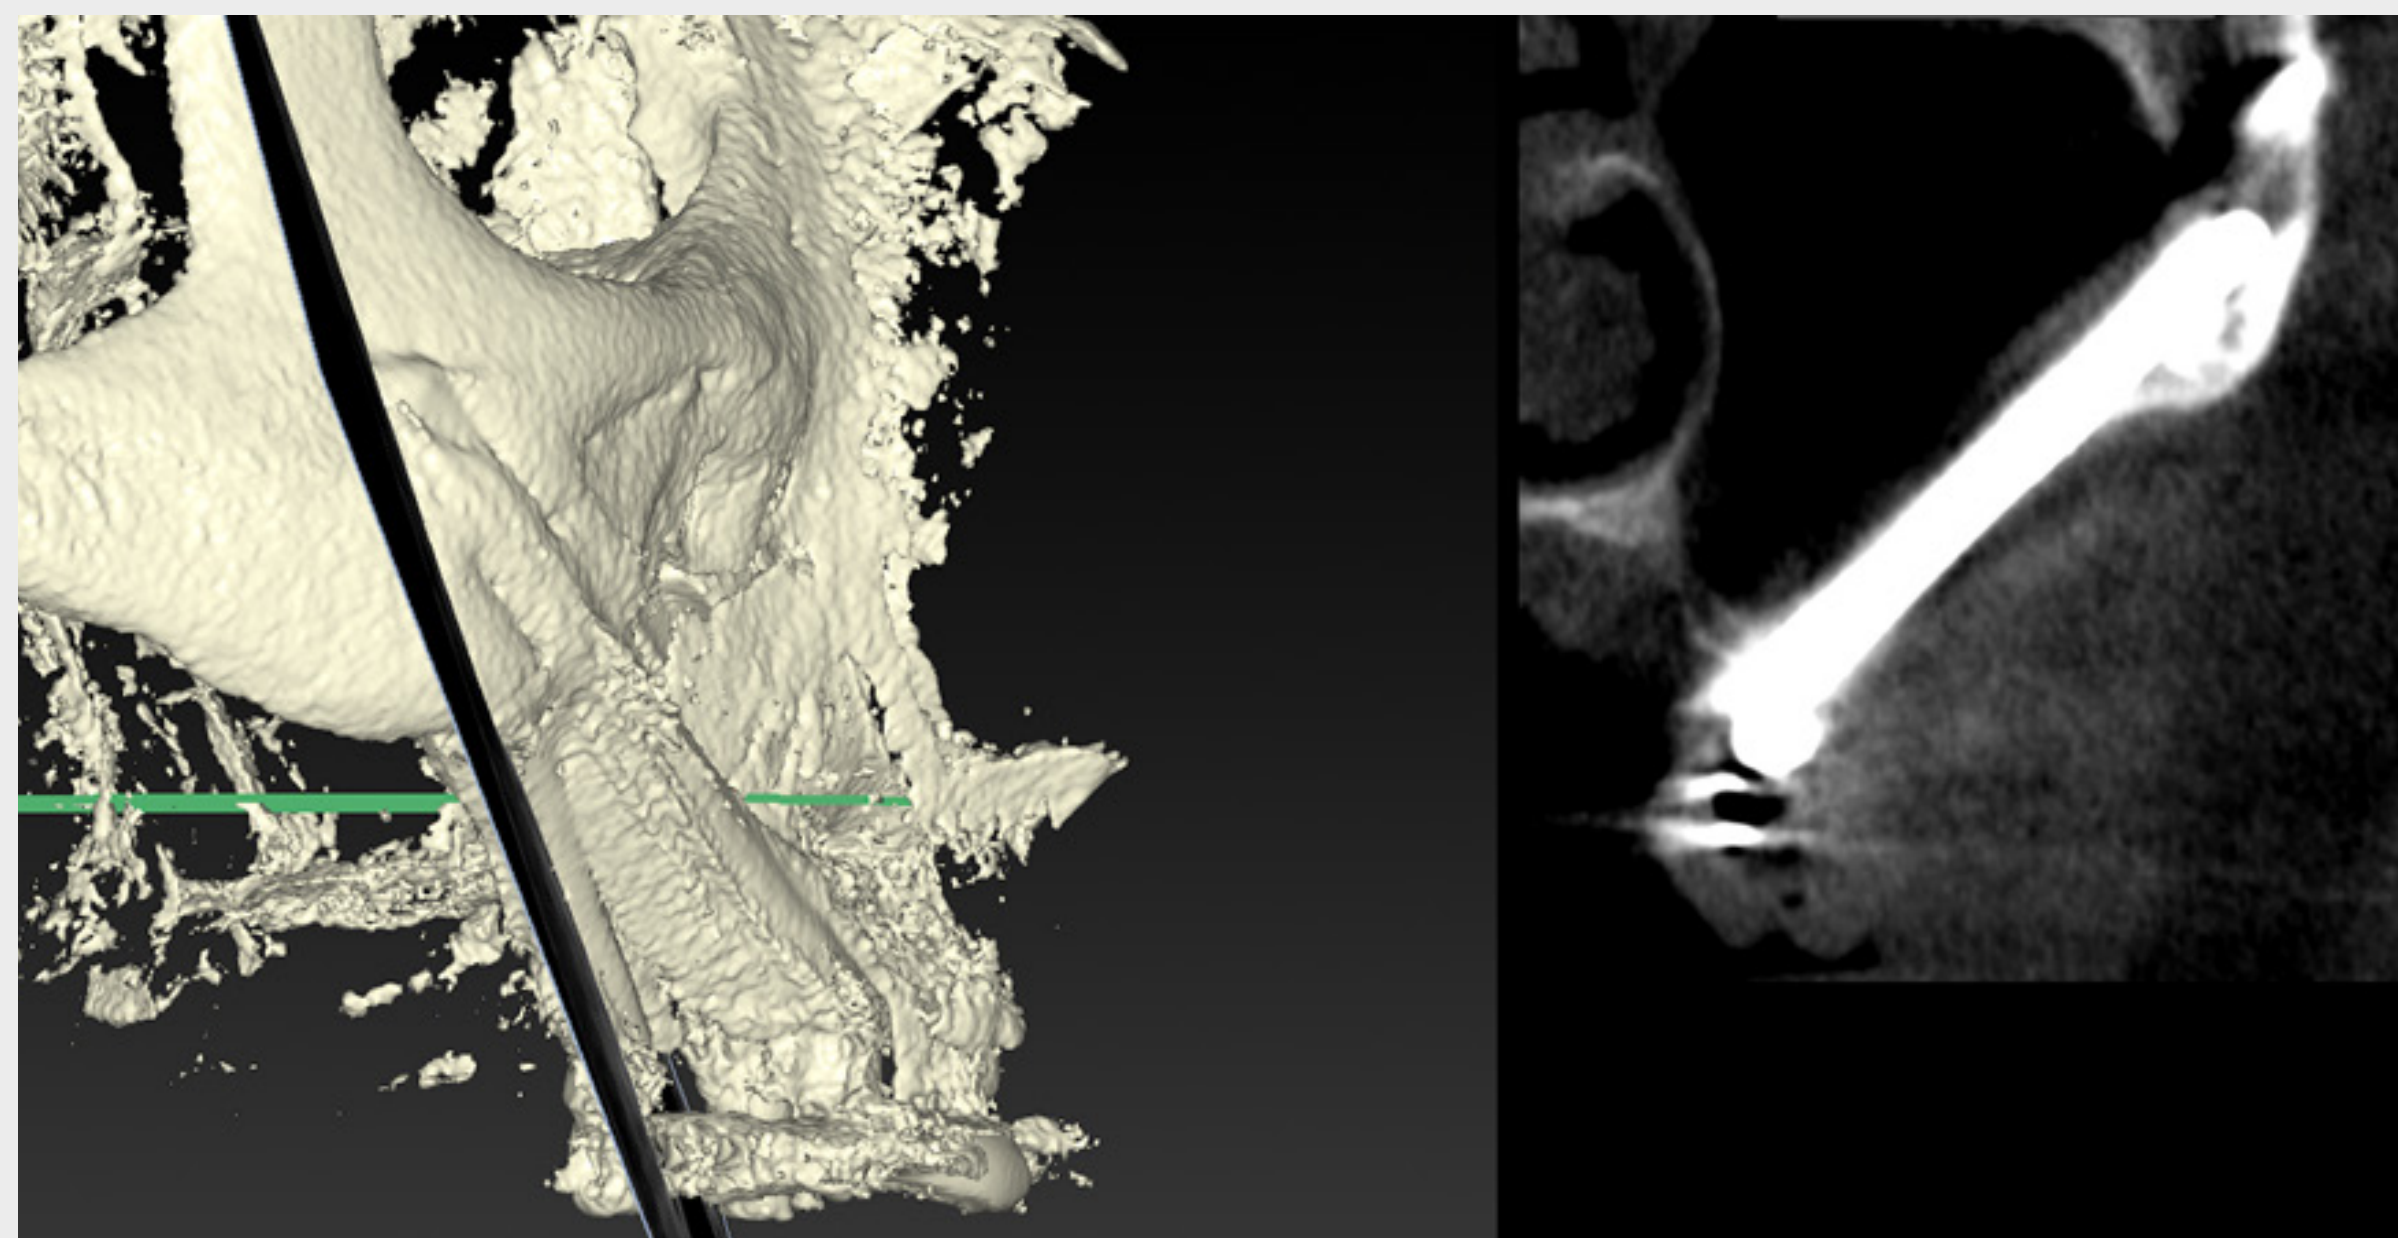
CBCT cut through the posterior right implant (ZAGA™ Type 4 - Straumann® Zygomatic implant, ZAGA™ Flat,) showing the transparency of the maxillary sinus after one year. Compare with the pre-surgery status shown in figure 4b.
